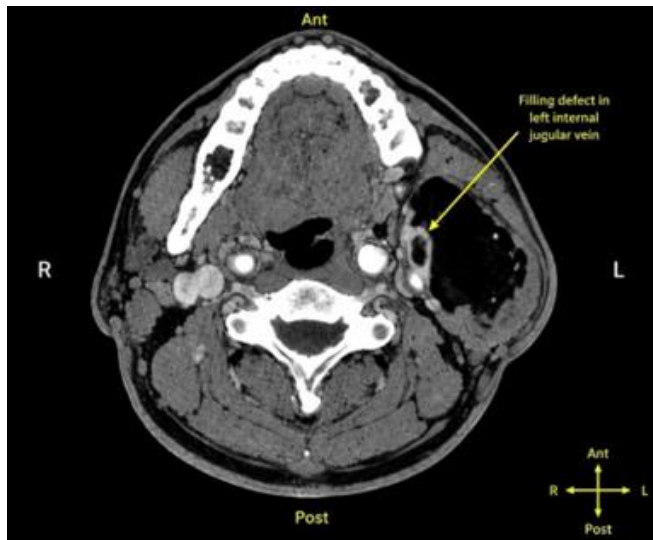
Contrast-enhanced computed tomography of the neck showing left internal jugular vein thrombosis. Axial contrast-enhanced computed tomography image demonstrating a non-enhancing intraluminal filling defect within the left internal jugular vein (arrow), consistent with internal jugular vein thrombosis.
